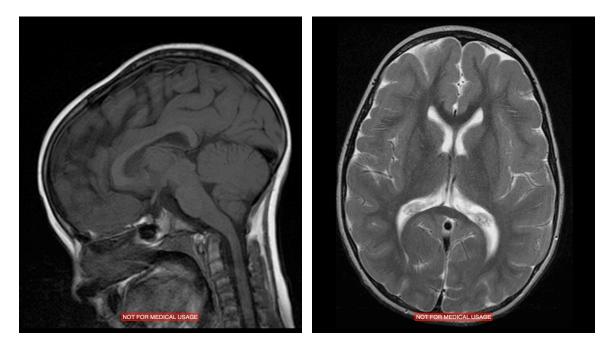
Axial MRI brain of individual DC-7801 MRI images show subcortical band heterotopia
